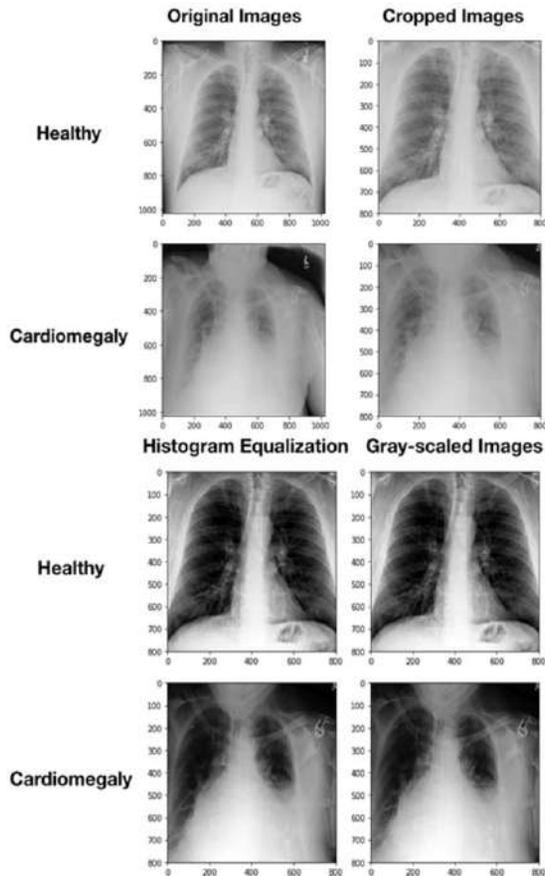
X-ray Images after Cropping and Histogram Equalization.
